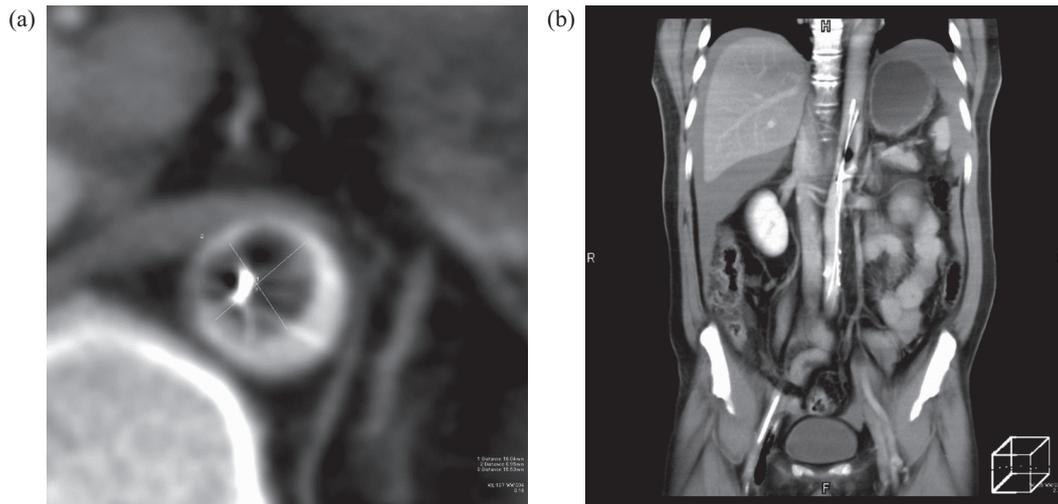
CT image of REBOA-TPS.
